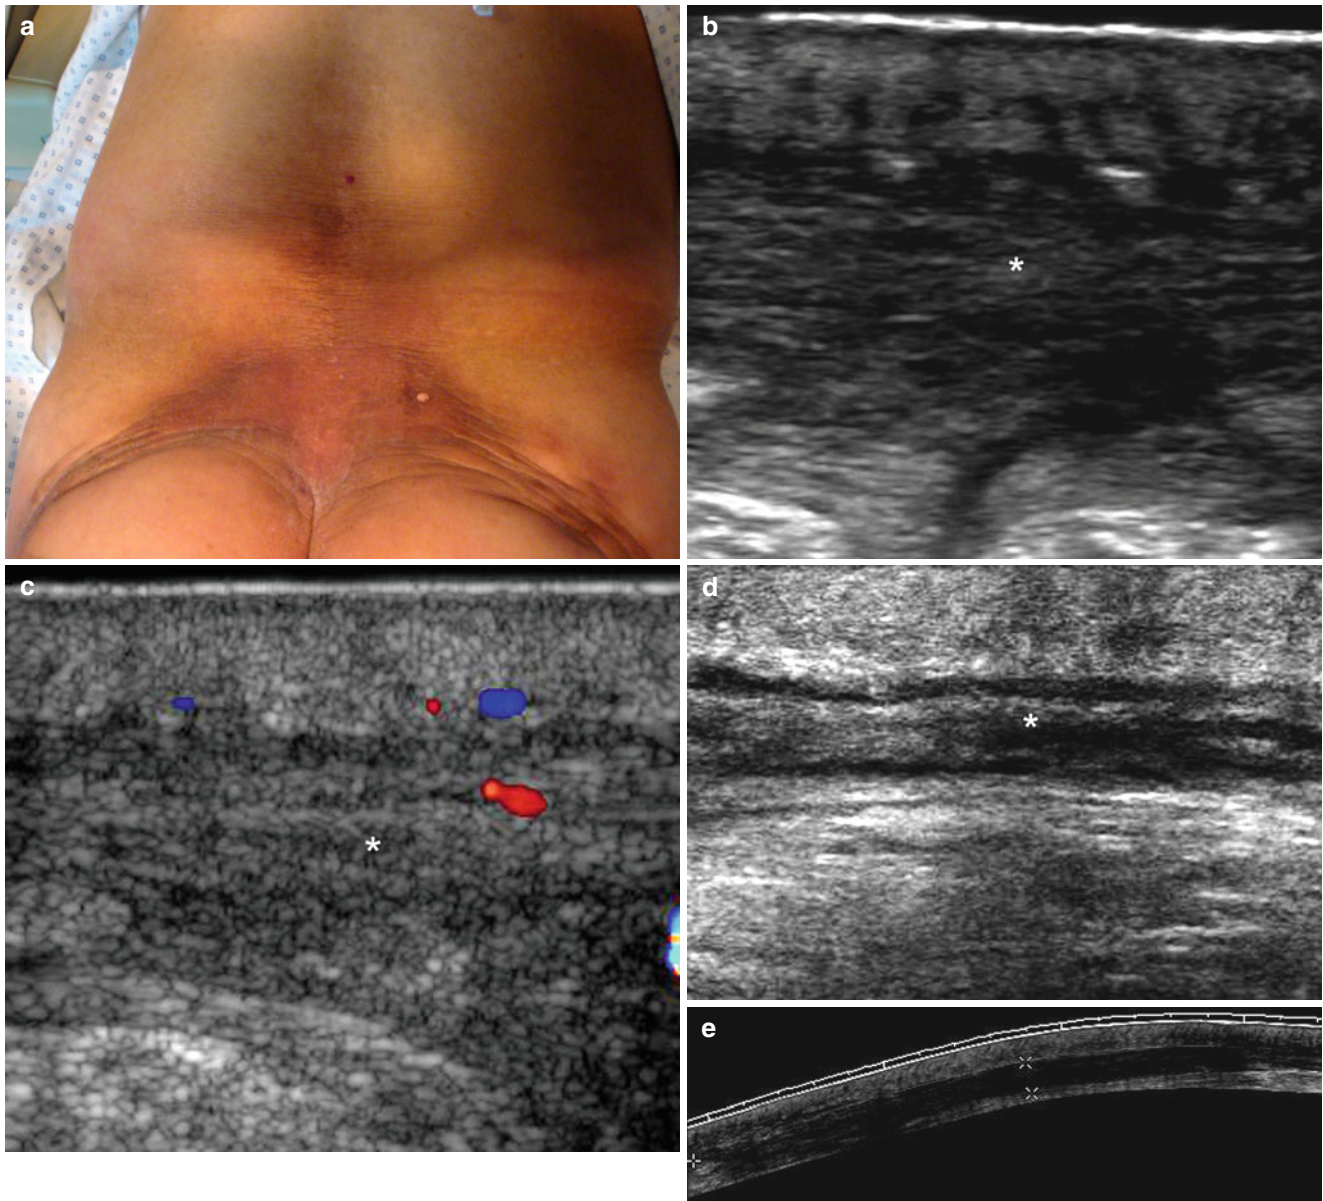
(a–e) Deep morphea-eosinophilic fasciitis. (a) Clinical lesion shows hyperpigmented and indurated plaque in the lumbar and gluteal region. (b) Gray scale ultrasound image (transverse view) demonstrates increased thickening and decreased echogenicity of the fascial plane (*). There is also decreased echogenicity and thickening of the dermis. (c) Color Doppler ultrasound image (transverse view) shows
